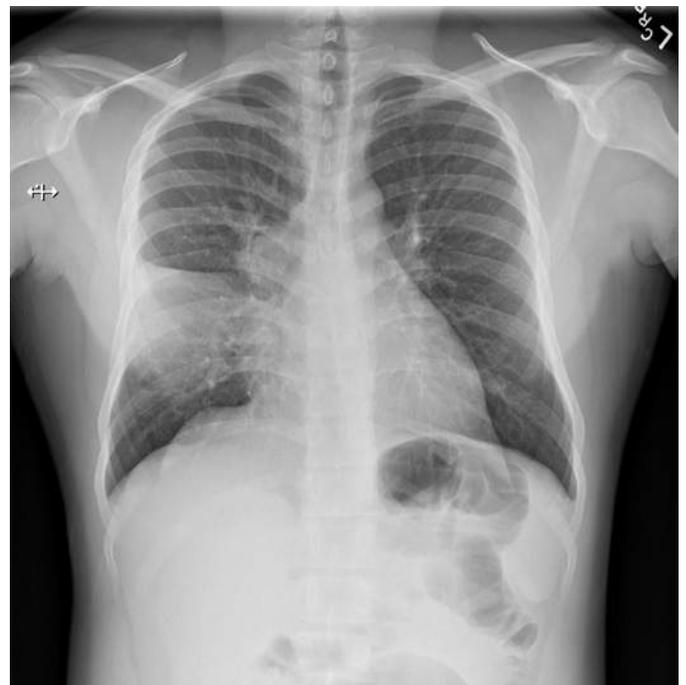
Lobar pneumonia caused by *Streptococcus pneumoniae*. A 36-year-old previously healthy woman presents with abrupt onset of fevers and shaking chills, cough productive of yellow sputum, and right-sided pleuritic chest pain. Chest radiograph reveals lobar consolidation. Sputum culture yields *S. pneumoniae*.
